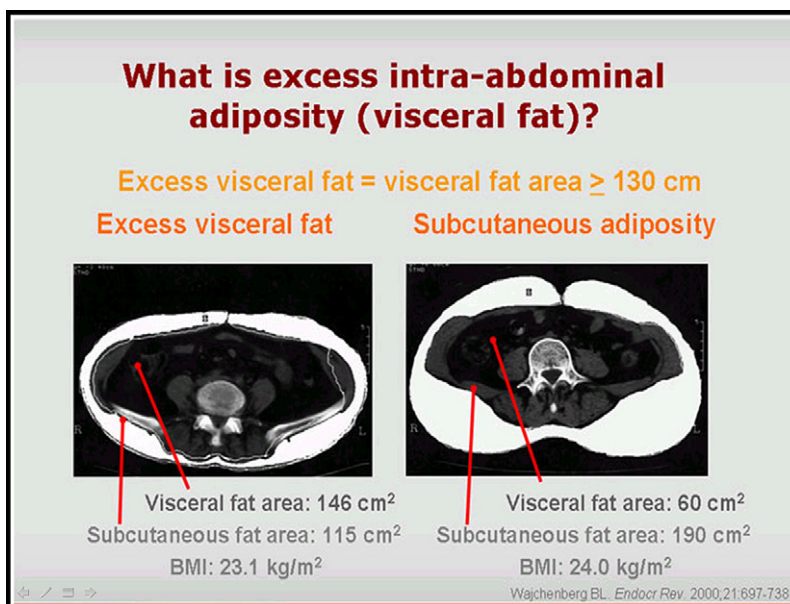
CT scan of patients with excess visceral fat (left) and subcutaneous adiposity (right).
